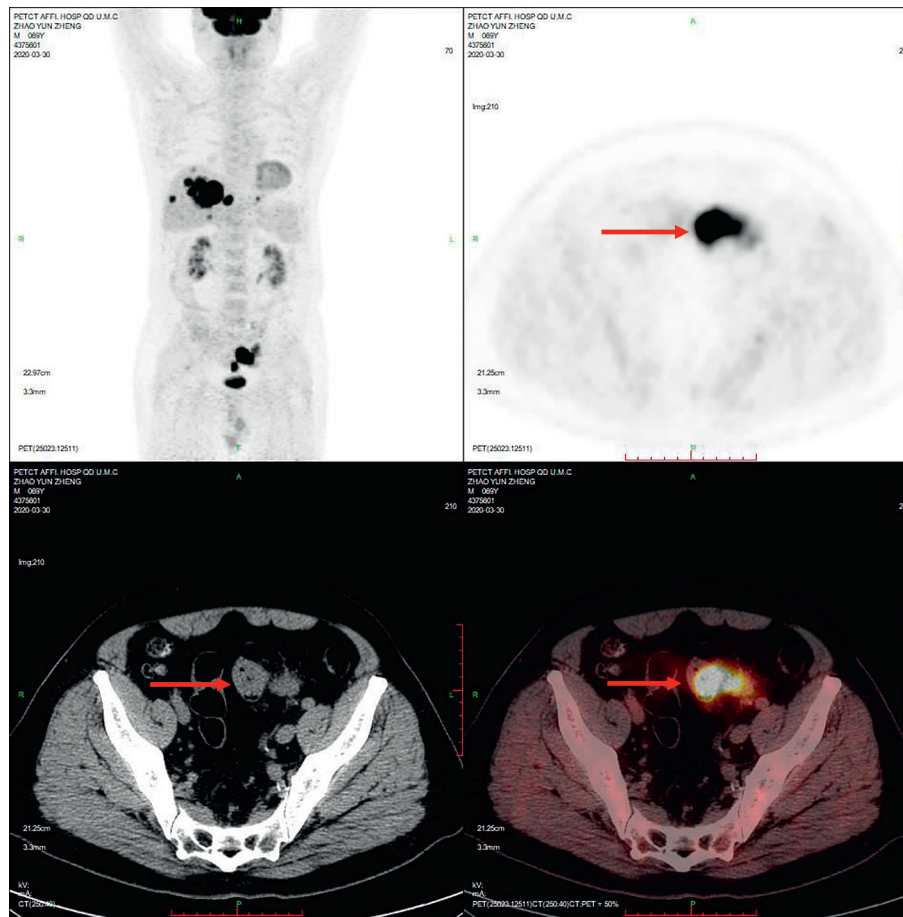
Male, 69 years old. Sigmoid colon cancer lesions significantly uptake FDG (SUVmax, 37.6). The SUVmax of peri-intestinal metastases was about 8.4.
